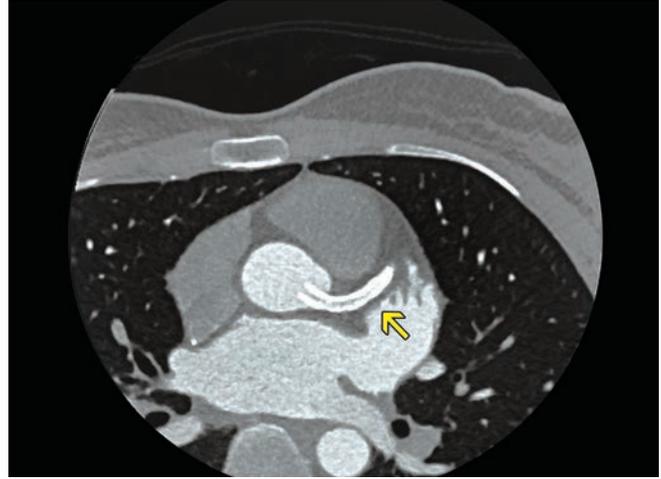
CT scan. Arrow points to the stent protruding into the AO.
